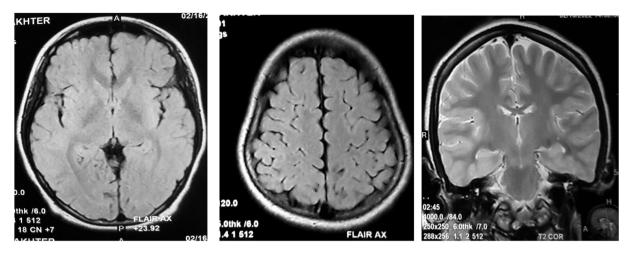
MRI brain reveals no abnormality in axial slice of the basal and parietal FLAIR and coronal slice around the hippocampus.
